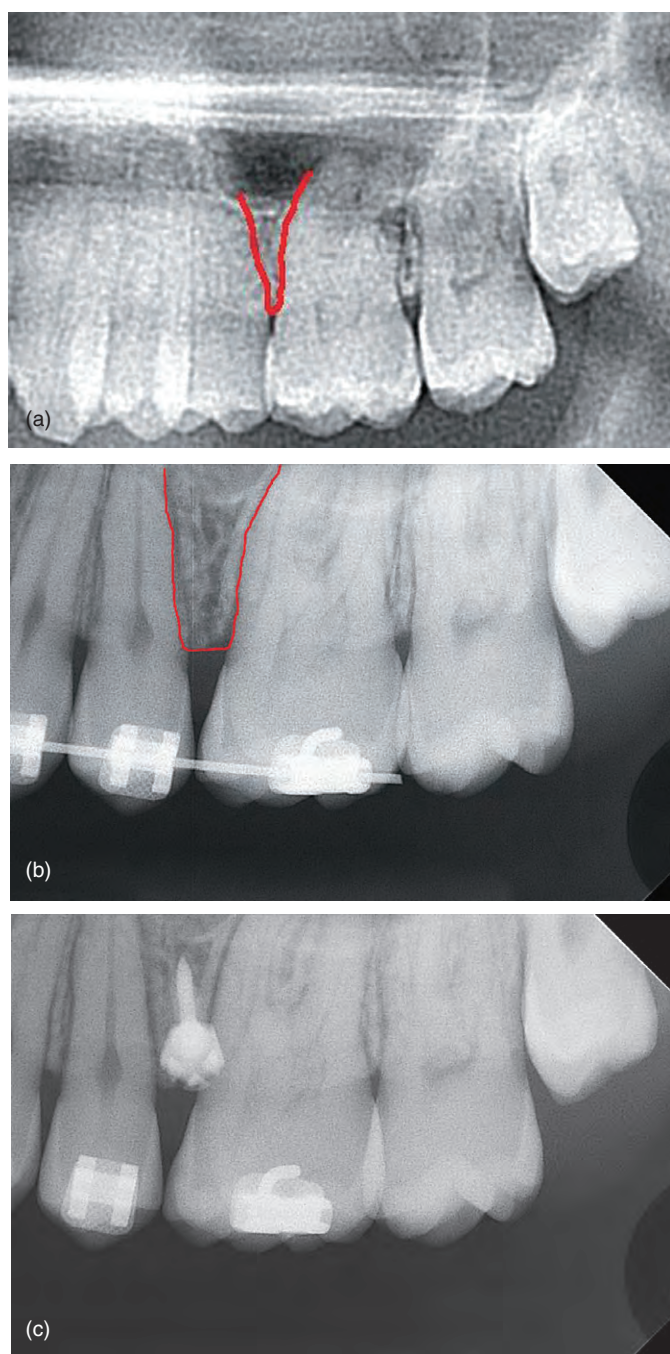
(a) A pre-treatment panoramic, and (b) pre-insertion and (c) post-insertion intra-oral radiographs. The insertion site between the left maxillary second premolar and first molar roots is highlighted in red in images (a) and (b). Root divergence has been performed to widen the interproximal space before radiograph (b) was taken.
